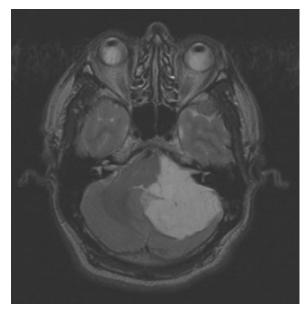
Epidermoid. Same patient as in Fig. 3. T2weighted magnetic resonance image shows an inhomogeneous high-intensity lesion.
